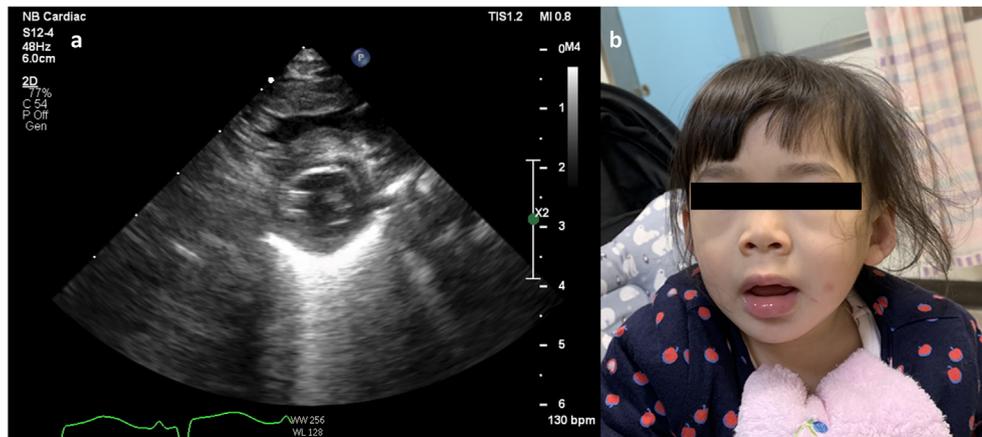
Clinical features of the patient. (a) Echocardiography which revealed cardiac hypertrophy and outflow tract obstruction. (b) Facial features of the patient.
